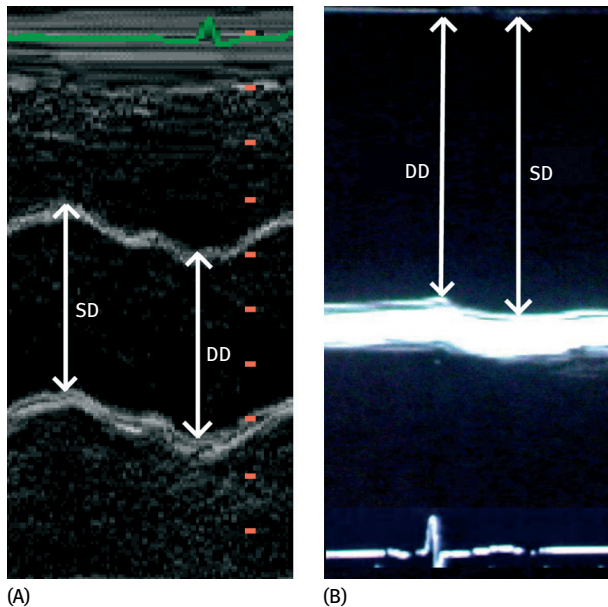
With TTE, SD and DD can be recorded in M-mode at a level of 3 cm above the aortic valve from a parasternal long-axis view. The SD and DD can be measured at the time of maximum aortic anterior motion and at the peak of the QRS complex, respectively (Figure 1A). With TEE, diameters should be measured at each level of descending aorta with M-mode (Figure 1B).
